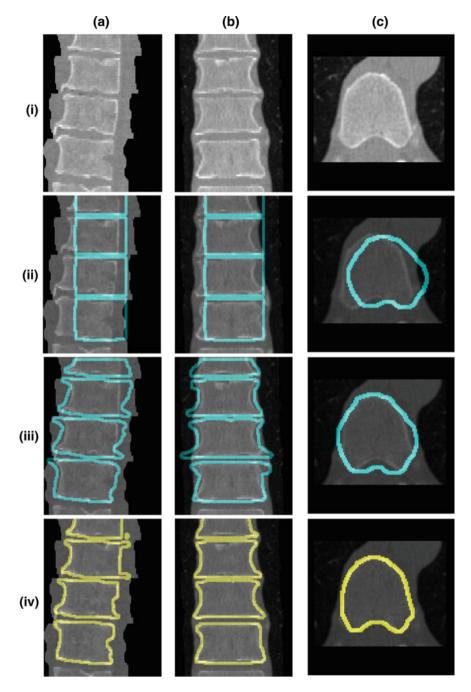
Embedding the shape model to the image domain and the final segmentation. (*i*) A CT data after the extraction of spinal cord. (*ii*) Shape model initialization (the *blue color* show the outer surface of the variability region J). The contour J is placed equally in every slice using the obtained ROI. (*iii*) Embedding the shape model to the image domain. (*iv*) Final segmentation using three models: The intensity, spatial interaction, and shape information. Images and results are shown in the (*a*) sagittal, (*b*) coronal, and (*c*) axial views
